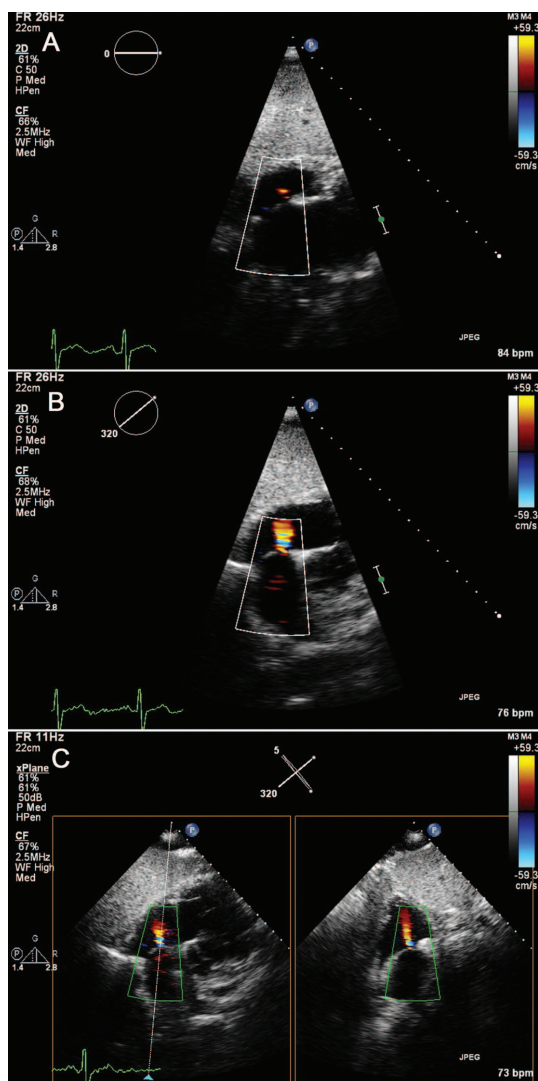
Atrial septal defect. A. subcostal four-chamber view with colour Doppler suggestive of a small atrial septal defect at 0° . B. iRotate at 320° reveals the exact origin of the defect. C: xPlane with a lateral tilt of 5° showing the long and short-axis views of the atrial septal defect.
